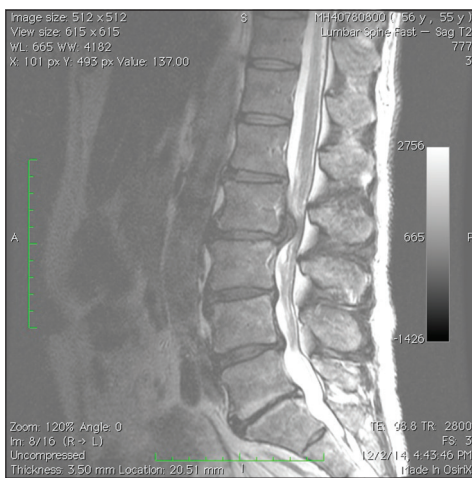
The preoperative December 2014 magnetic resonance imaging parasagittal study documented a massive central-left sided L2–L3 lumbar disk herniation resulting in severe thecal sac and left L2 and L3 foraminal/lateral recess root compression respectively. Notably the right mild/moderate sequestered L4–L5 disc was asymptomatic
